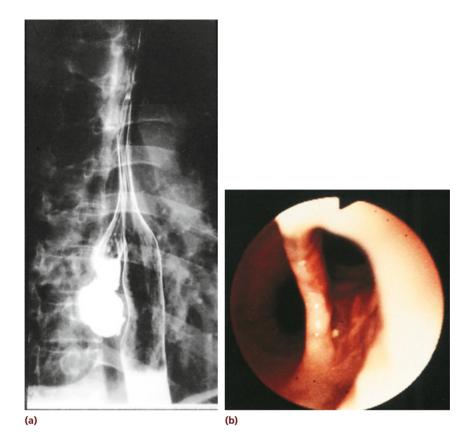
(a) Radiograph showing a large, congenital, tubular duplication of the esophagus. (b) Endoscopic view showing the opening to the tubular duplication (right) and esophageal lumen (left). Congenital esophageal duplications may be tubular or cystic.
